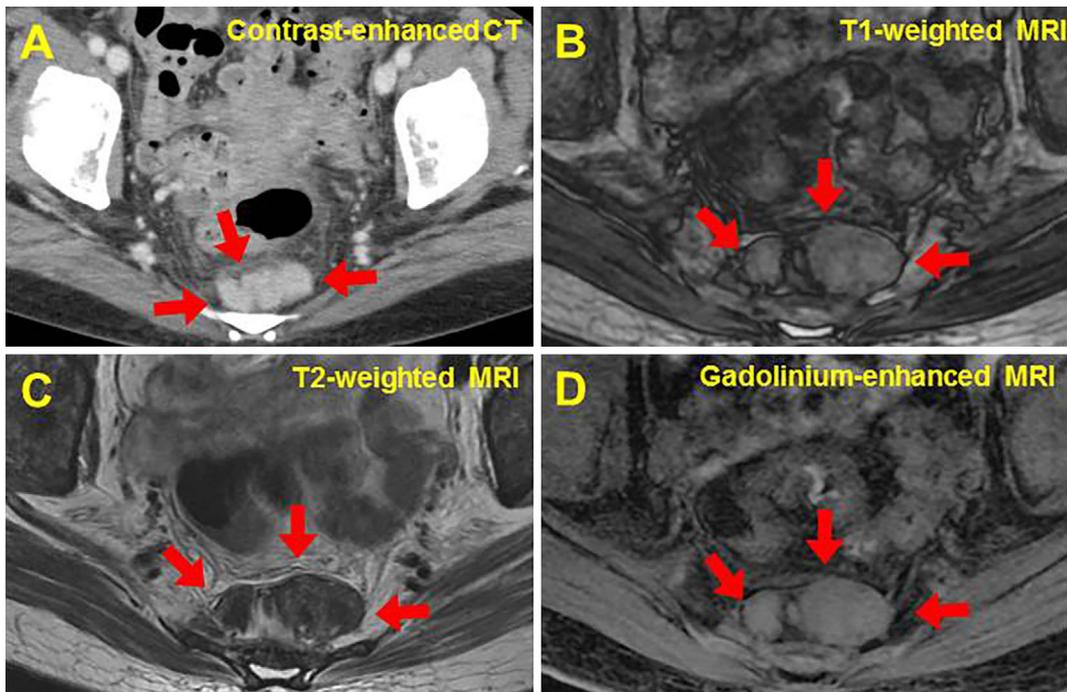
Computed tomography (CT) and magnetic resonance imaging (MRI) of the presacral extramedullary hematopoiesis. (A) Contrast-enhanced CT reveals a lobulated and well-margined mass (arrows) in the presacral region. (B-D) MRI shows that the mass (arrows) is iso- or high-intensity on T1-weighted (B) and hypo-intensity on T2-weighted (C) images and that it is diffusely enhanced after the intravenous injection of gadolinium (D).
